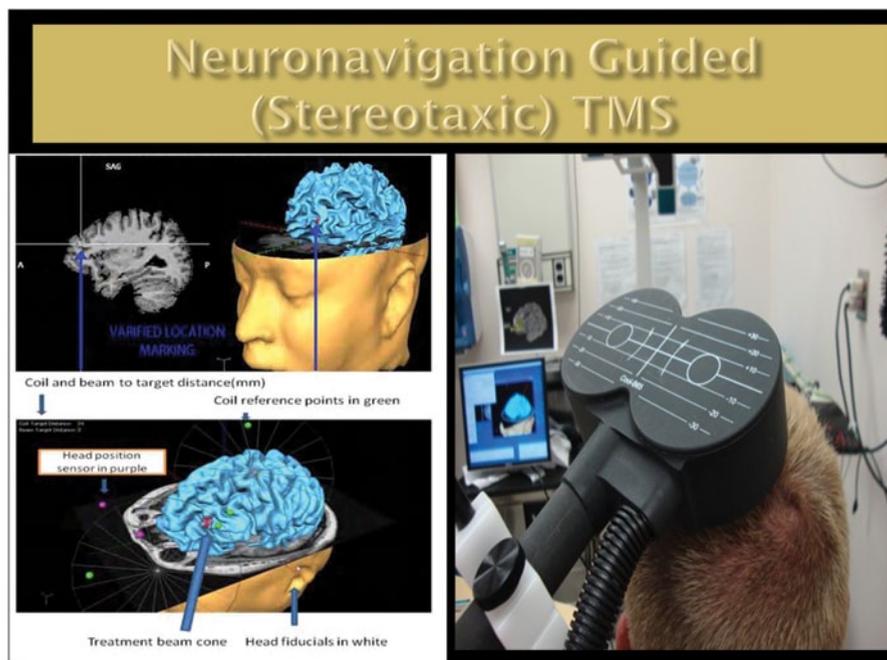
Brain-MRI-based stereotaxic neuronavigation-guided TMS. The established treatment site is marked on the surface of the cortex so that each treatment is provided at the same location. TMS transcranial magnetic stimulation
